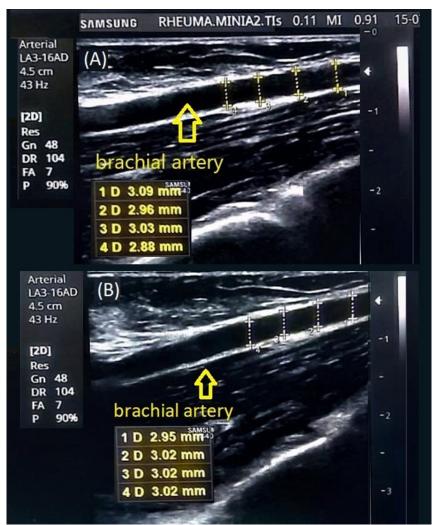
Flow-mediated dilatation (FMD%) in psoriatic arthritis patients. This figure demonstrates ultrasonography of the brachial artery 3cm above the elbow. Panel A shows the brachial artery lumen longitudinal distance before occlusion by sphygmomanometer cuff. B is the lumen within 1 min after 5 min of occlusion period.
